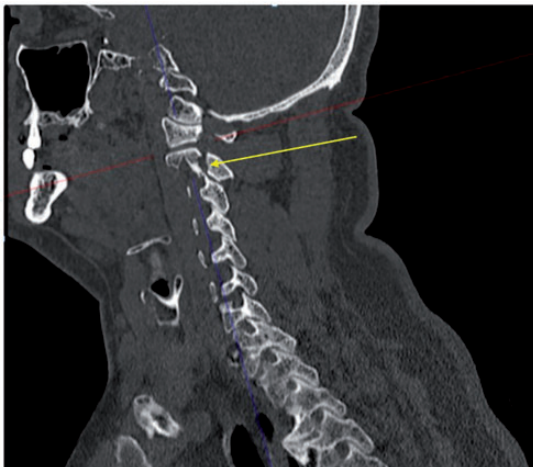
Axial view of CT demonstrating traumatic spondylolisthesis of the axis.
